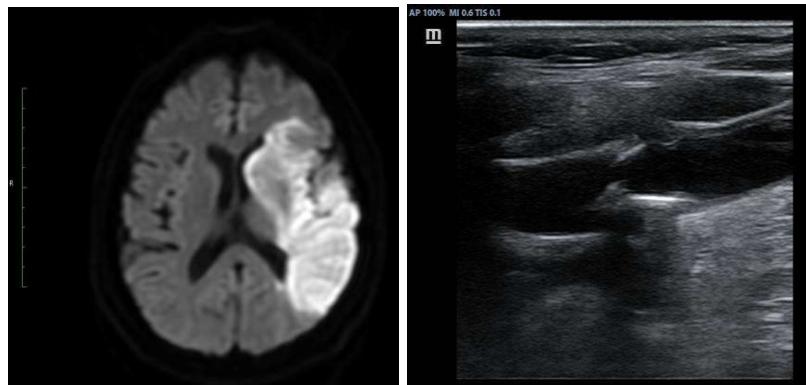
MRI-DWI image shows restriction in left caudate nucleus, internal capsule, M1, M2 & M3 in MCA artery distribution in a patient presenting with hemiparesis
